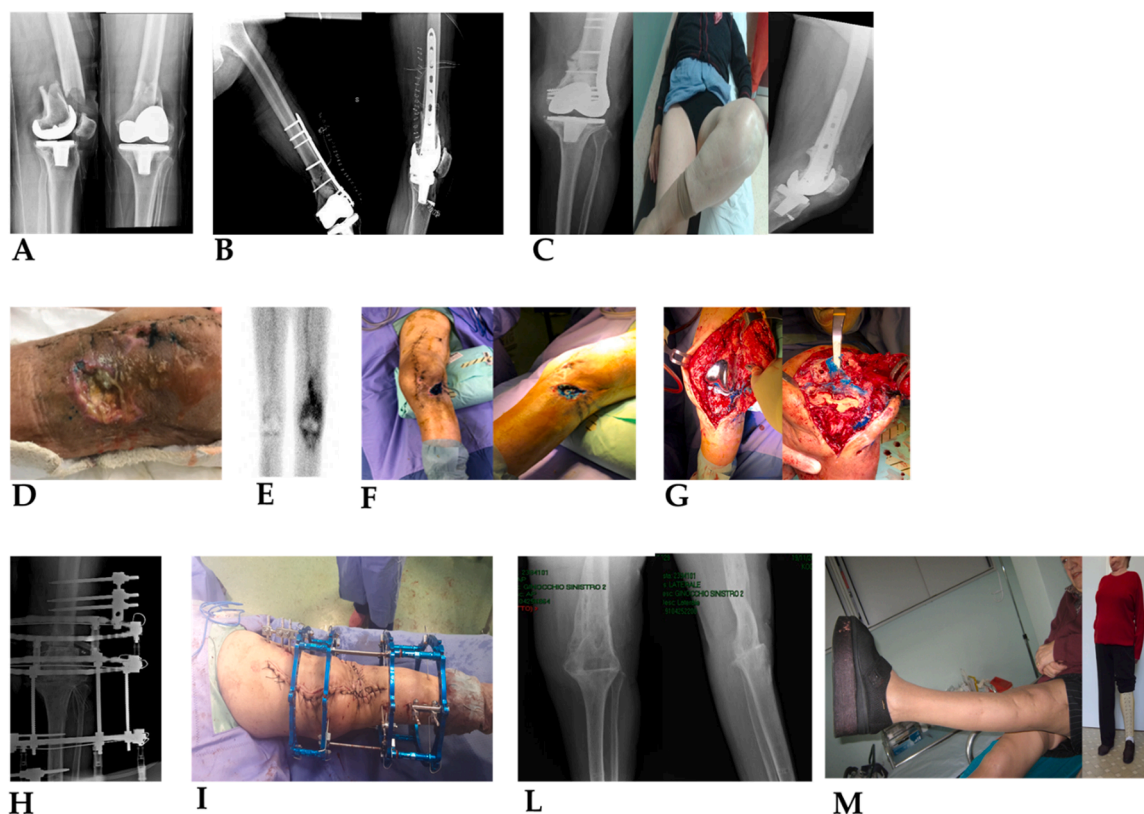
(A): periprosthetic fracture type II according to Rorabeck's classification; (B): reduction and synthesis with plate and screws; (C): RX after 10 months; (D): clinic after 10 months with purulent fistula positive for MRSA; (E): scintigraphy + for osteo and prosthetic infection; (F): in view of soft tissue distress, MRSA positivity, scintigraphic involvement of the prosthesis, no possibility of coverage, and the patient's age, removal of the prosthesis after instillation of methylene blue is performed; (G): intraoperatively with the tracer reaching the prosthesis and bone, visible even after removal of the prosthesis and the plate and screws; (H): RX after compaction and arthrodesis with circular EF; (I): clinic with fixator; (L): RX after 1 year; (M): clinic after 1 year.
